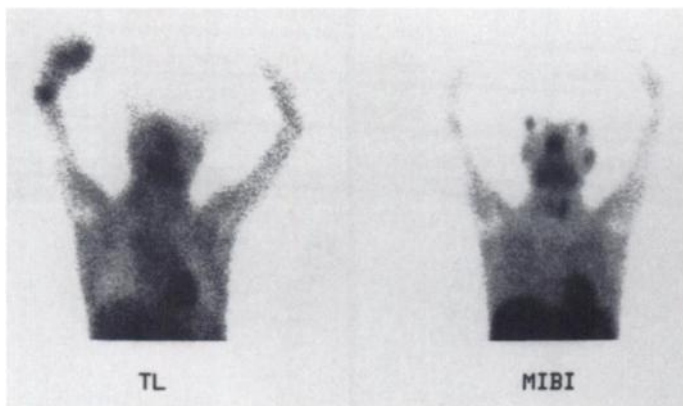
A 4-yr-old boy (Patient 18) with NHL, who had right cervical and mediastinal masses visualized by ^{201}Tl (left) scintigraphy. Technetium-99m-sestamibi (right) uptake was absent in these lesions. Visual grading scores and T/B ratios for cervical and mediastinal masses were 2+, 1.18 and 3+, 1.34, respectively, in the ^{201}Tl study. The patient demonstrated no response to subsequent chemotherapy.
